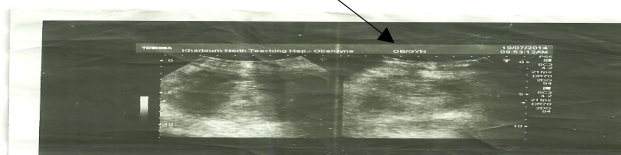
Figure four: 70 old Ultrasound show cervical mass
